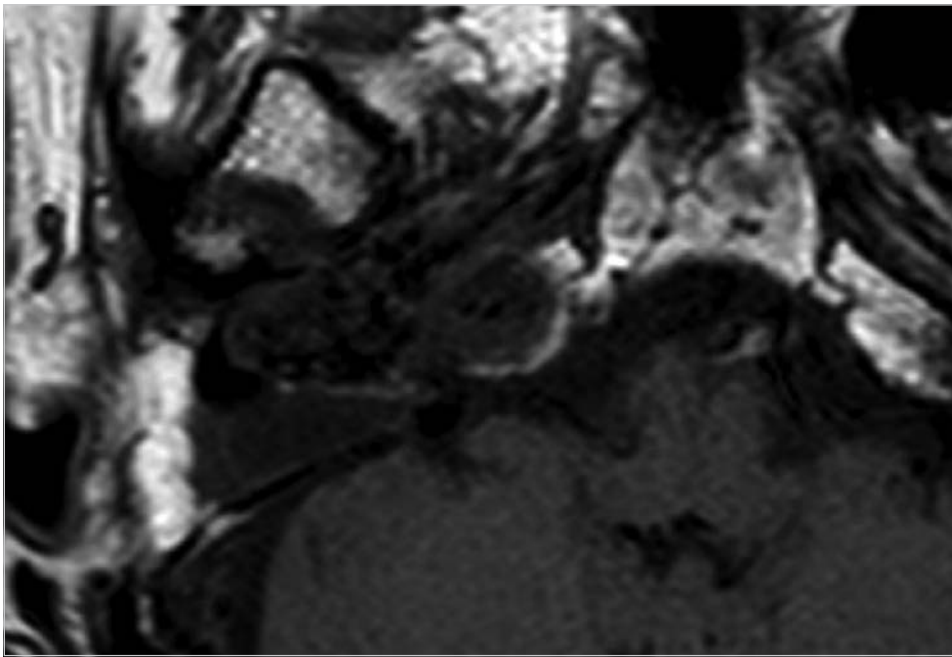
In T1-weighted image, the area shows low signal intensity. Identification of each structure inside the temporal bone is not possible.
